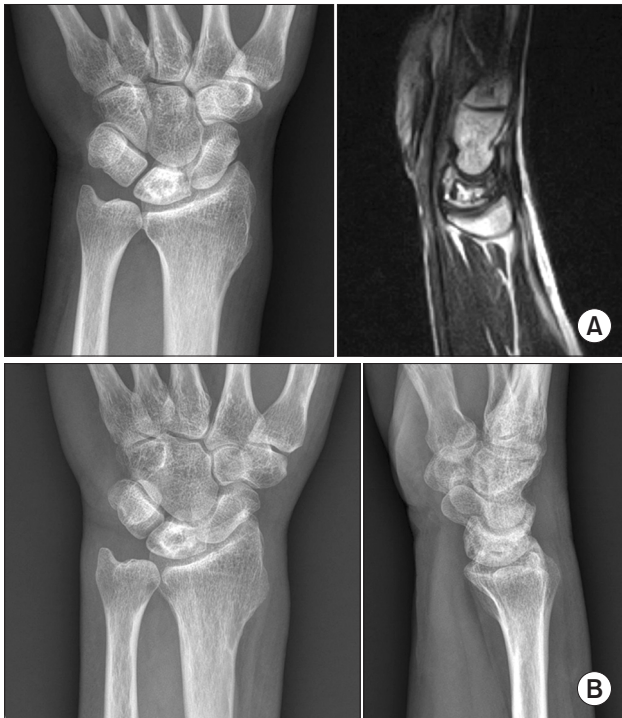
Wrist pain in a 57-year-old man, mainly located on the ulnar side of the wrist. (A) The plain radiograph showed a large cystic lesion in the lunate and a positive ulnar variance. Magnetic resonance imaging showed a geographic bone lesion surrounded by low-signal rim inside the lunate, indicative of Kienböck's disease (Lichtman stage 2). (B) Follow-up of 7.2 years resulted in no further collapse in the lunate and no arthritic involvement. Intermittent pain control and lifestyle modification of avoiding the pronated position of the forearm resulted in favorable clinical outcome.
